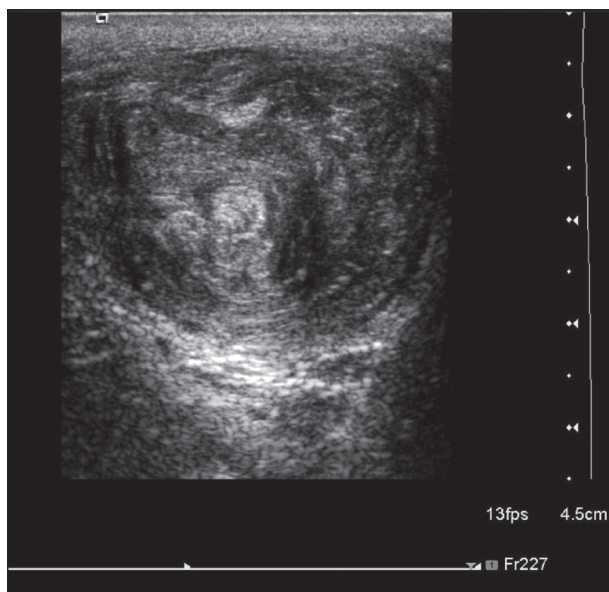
Sonogram TS showing the whorly appearance of the tumor
